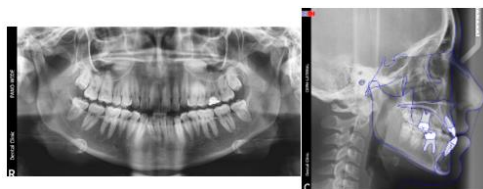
Initial Panoramic Radiograph and Cephalometric Tracing
